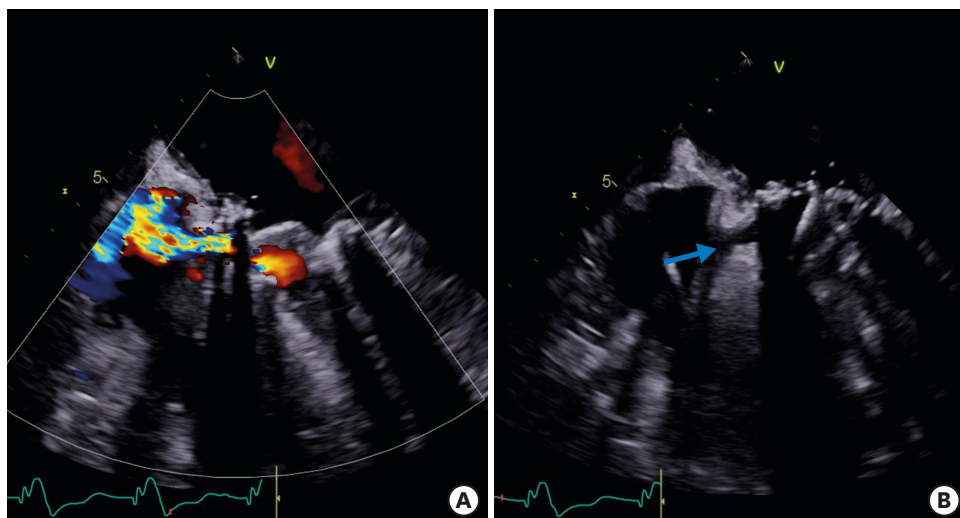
Transesophageal echocardiogram (four-chamber view). (A) Color flow Doppler image showing systolic flow from the left ventricle to the right atrium. (B) The defect is shown on 2D imaging (blue arrow: Gerbode's defect).
